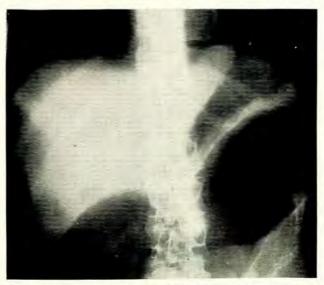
Plain supine X-ray of the abdomen of a middleaged woman with Crohn's disease of the large bowel who developed a 'toxic megacolon'.
